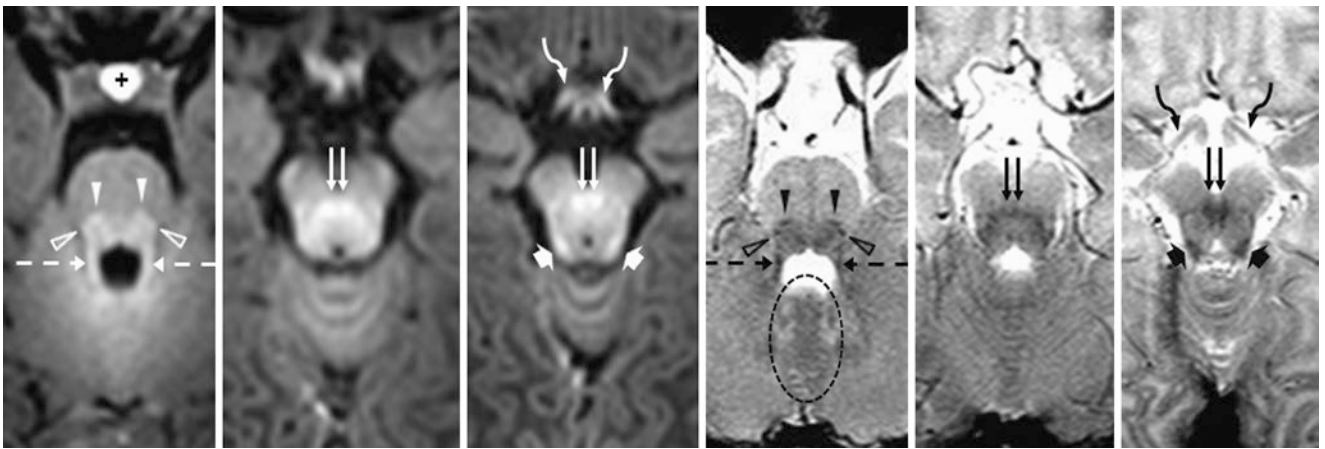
A 5-day-old term neonate had a normal 3T MRI with GE T1WIs (*left 3 images*) and SE T2WIs (*right 3 images*). The BIC/inferior colliculi (*wide arrows*), DSCP (*double arrows*), LL (*open arrowheads*), ML (*arrowheads*), optic tracts (*curved arrows*), and SCP (*dashed arrows*) all appear myelinated, along with normal “myelination” of the superior cerebellar vermis (*dotted oval*). Also, note the normal, homogeneously T1-bright pituitary gland (*plus sign*)
